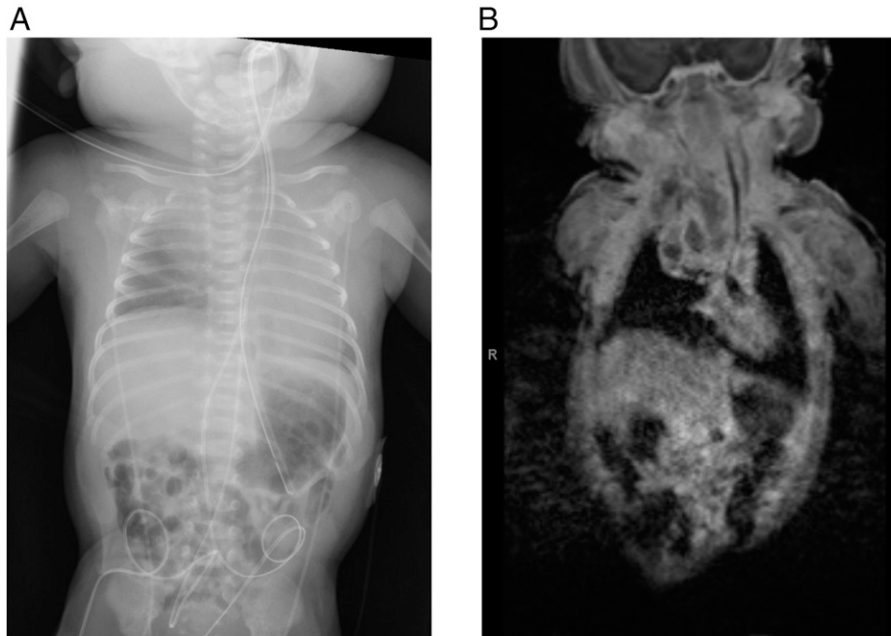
A. Radiograph showing deviation of the trachea and esophagus to the left. Soft tissue mass is also visible over the right upper lung fields. Right and left diaphragms are uneven. B. Coronal MRI showing a multiloculated cystic and septated mass with multiple fluid levels resulting in deviation of mediastinal structures.
